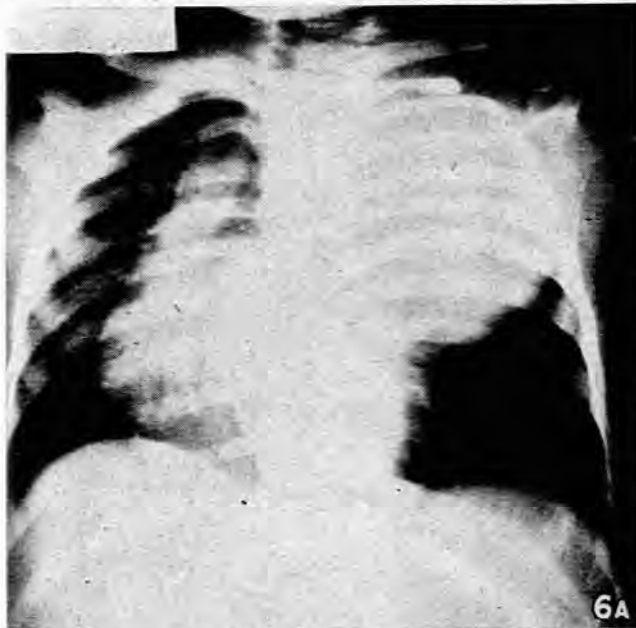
(A). A penetrating AP radiograph of a 2-year-old girl with a foregut duplication in the left upper chest.
